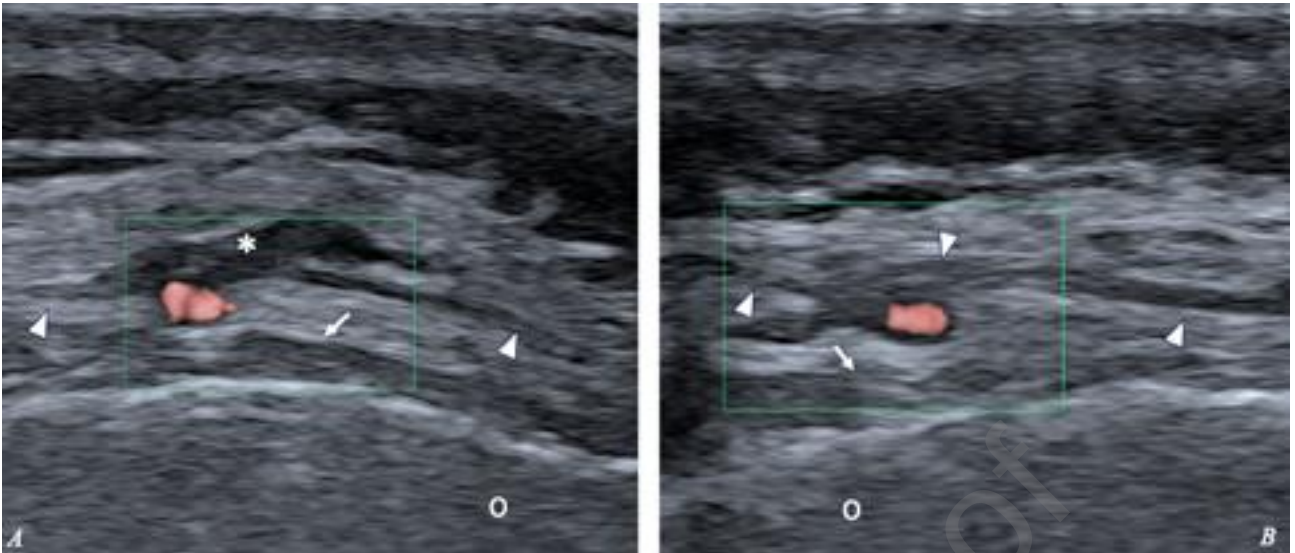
The images show the long axis view of a distal branch of the great occipital nerve (white arrowheads) in the subcutaneous tissue at the level of the superior nuchal line. On the affected side (7a), there is hypoechoogenic fibrotic tissue (white asterisk) surrounding the nerve at the point where it runs superficially to the occipital artery (red dot in the colored Power Doppler box). In 7b, contralateral normal findings. White arrow: aponeurosis of the trapezium that inserts on the occipital bone (O).
